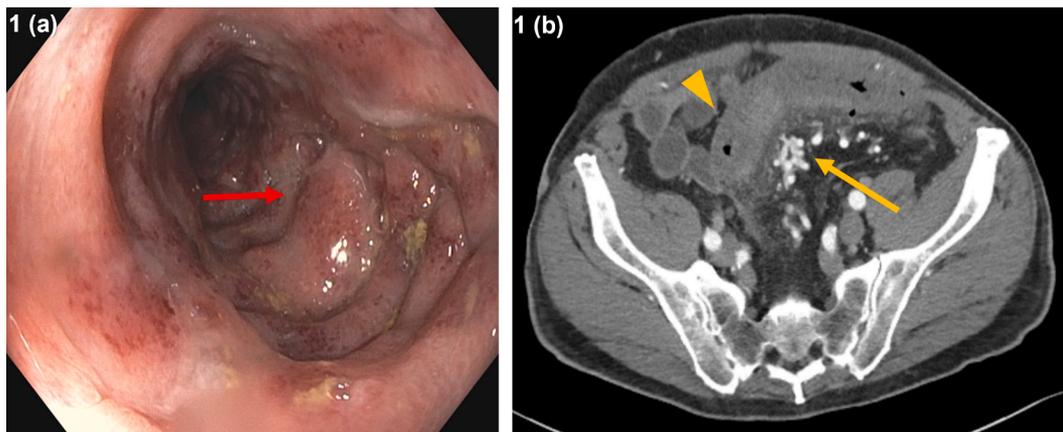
Case 1 — Endoscopic and radiographic findings of IMHVM.
